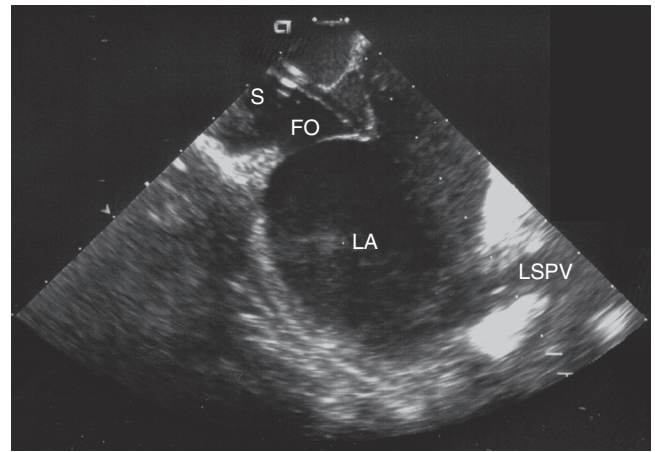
■ Intracardiac ultrasound image of transseptal catheterization. The transseptal sheath (S), fossa ovalis (FO), left atrium (LA), and left superior pulmonary vein (LSPV) ostium are shown. The typical "tenting" of the fossa ovalis by the transseptal needle advanced through the sheath confirms appropriate positioning of the needle for puncture of the fossa ovalis.
